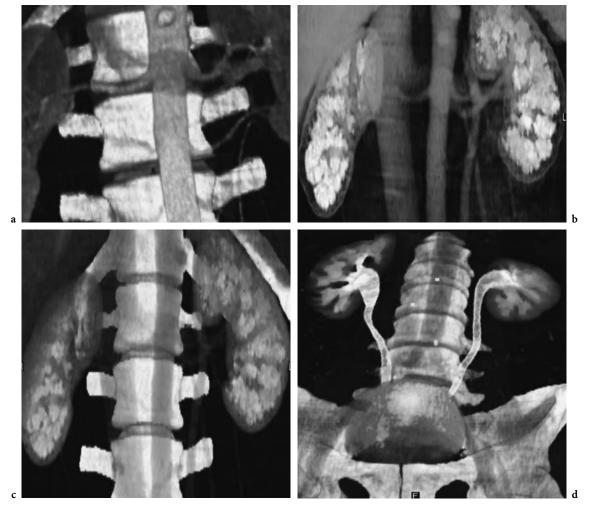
Multidetector CT evaluation in a potential renal donor. VR 3D images, obtained in the multiple phases of renal enhancement, perfectly demonstrate (a) normal renal arteries with left accessory artery, (b) normal renal veins, (c) regular renal dimensions, morphology and parenchyma condition, and (d) normal collecting systems
